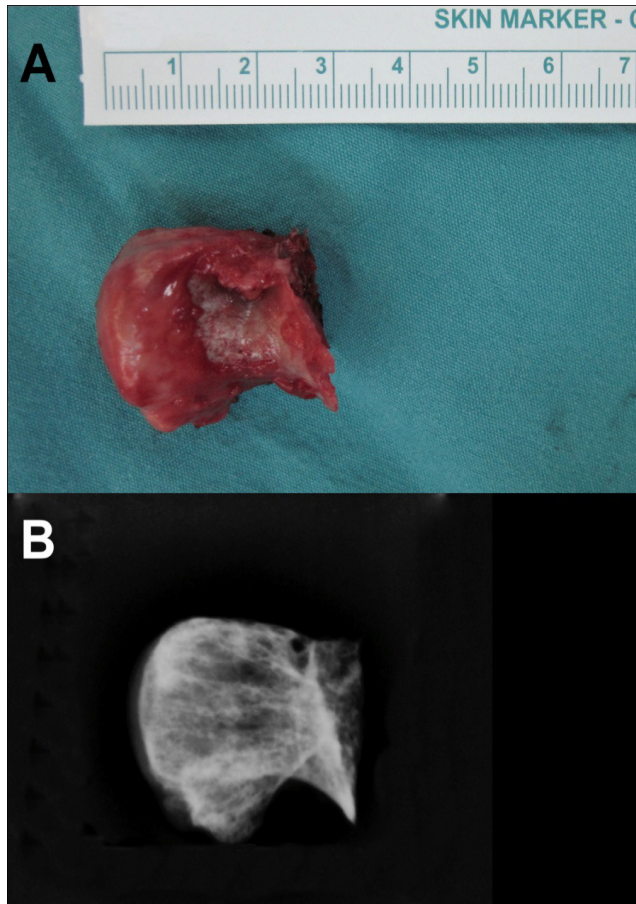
A) Macroscopic B) Radiographic view of the surgically excised osteochondroma.
